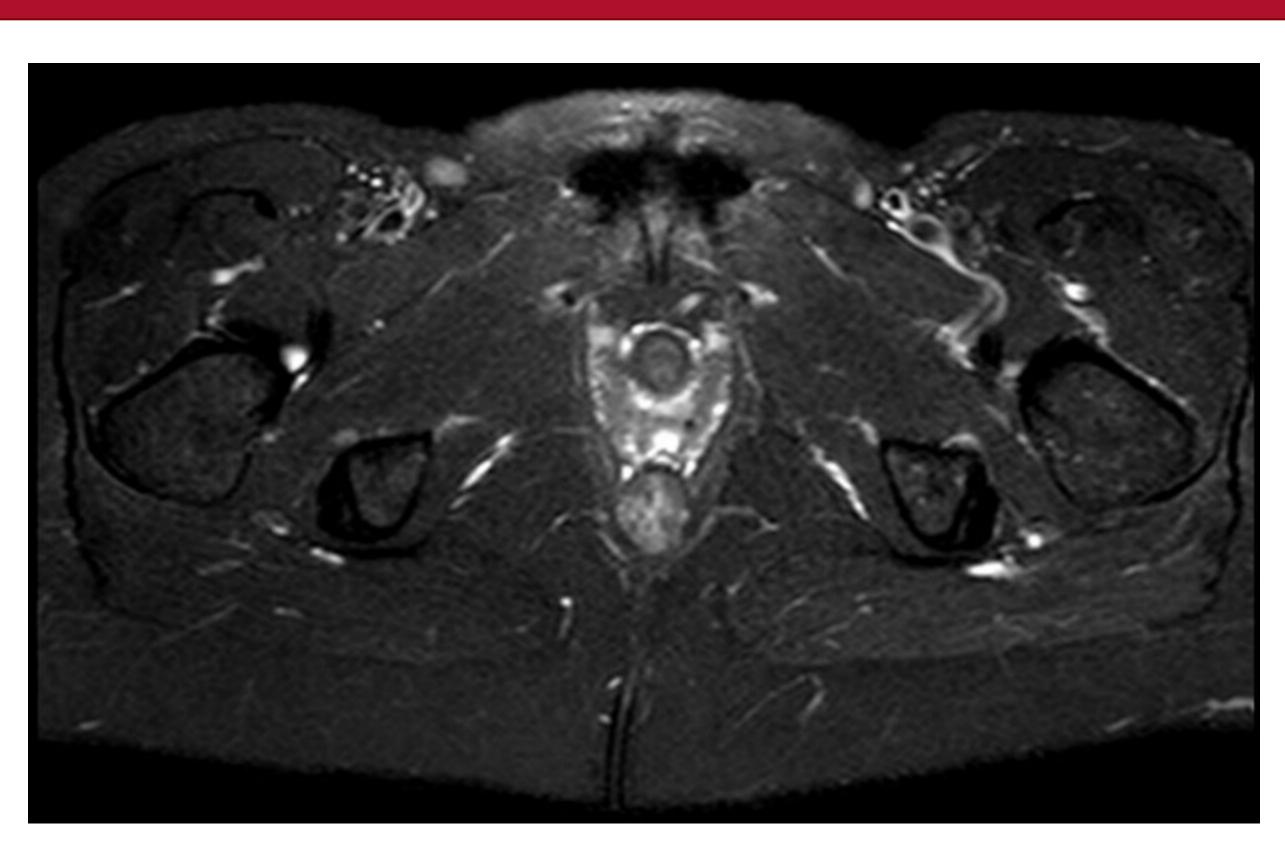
MRI Fistulogram The pouch is thickened and there is fluid around it compatible with pouchitis. There is a 5 mm area of fluid either within the central portion of the vagina with no visualized fistula
